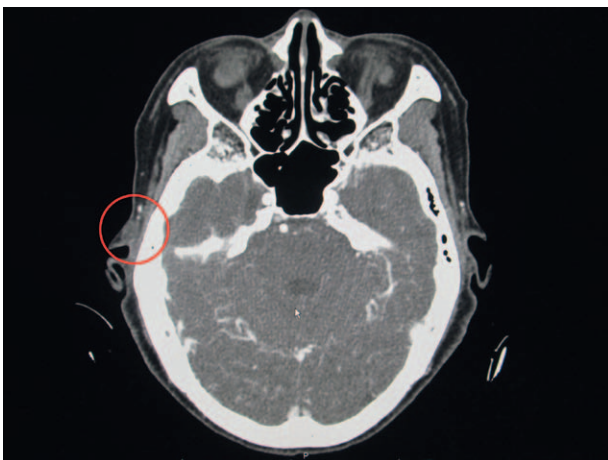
Reviewed computed tomography revealing a round mass (circle) between the right superficial temporal artery (white dot) and tragus. These findings are obvious when compared to the left side.
